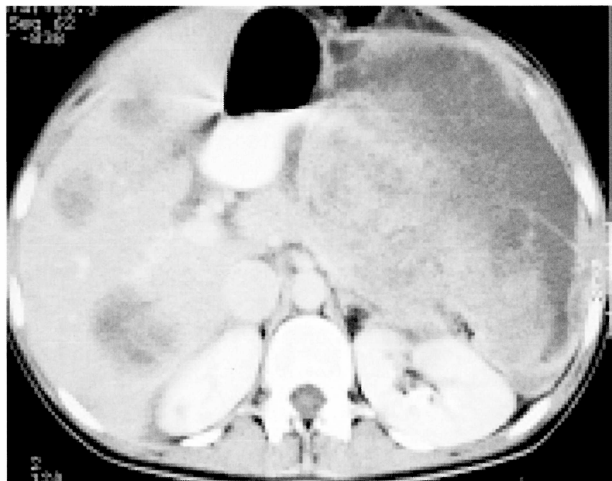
Abdominal computed tomography scan showed a voluminous cystic and solid tumor in the left mesogastrium and hypogastrium and multiple hepatic metastases involving both lobes.
